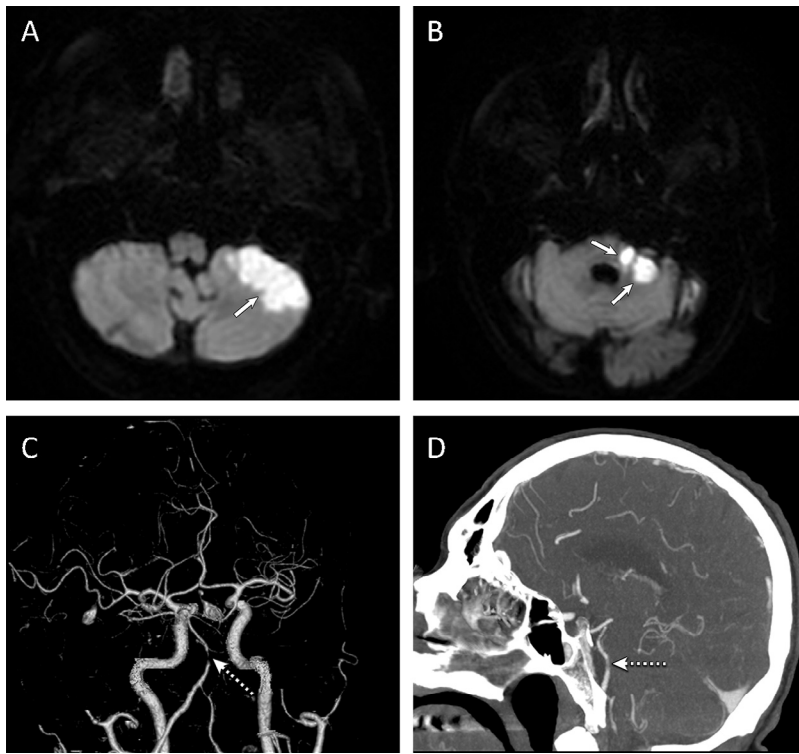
Case 1 presents a 67-year-old male patient with acute left facial numbness and facial droop. Diffusion-weighted magnetic resonance images show increased signal in the left (A) petrosal surface of the cerebellum and flocculus (B) middle cerebellar peduncle, with low signal on the corresponding Apparent Diffusion Coefficient (ADC) map (not shown) consistent with an acute infarct. A computed tomography angiogram showed focal stenosis of the midportion of the basilar artery (dashed arrow) as seen on the (C) 3-dimensional image and (D) sagittal maximum intensity projections.
